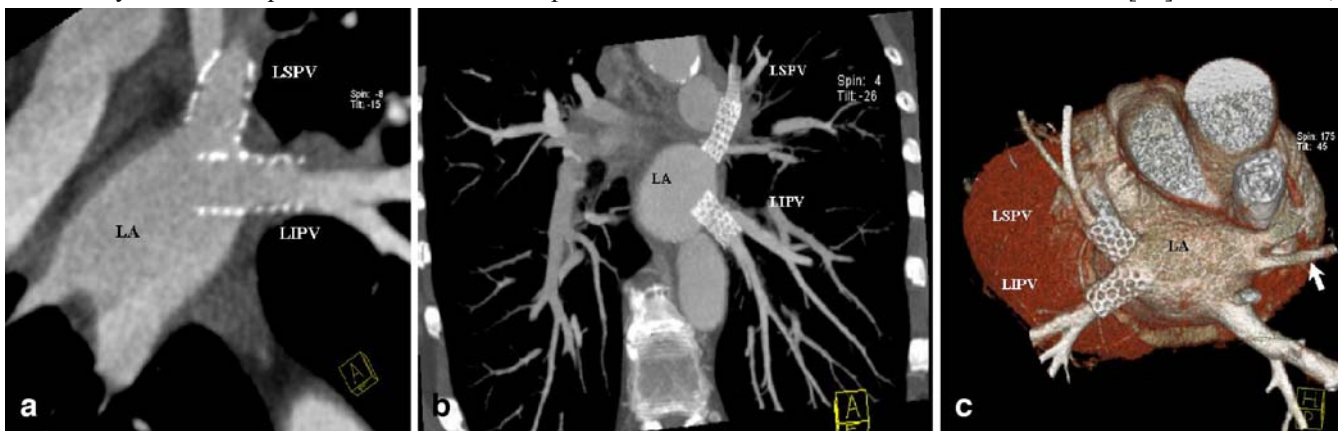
Stents on left superior and left inferior pulmonary veins (PVs). Maximum intensity projection of multidetector-row computed tomography (MDCT) images in oblique axial (a) and coronal (b) projection and volume rendering technique reconstruction, posterior view (c), of PVs after MDCT angiography depicts stents
